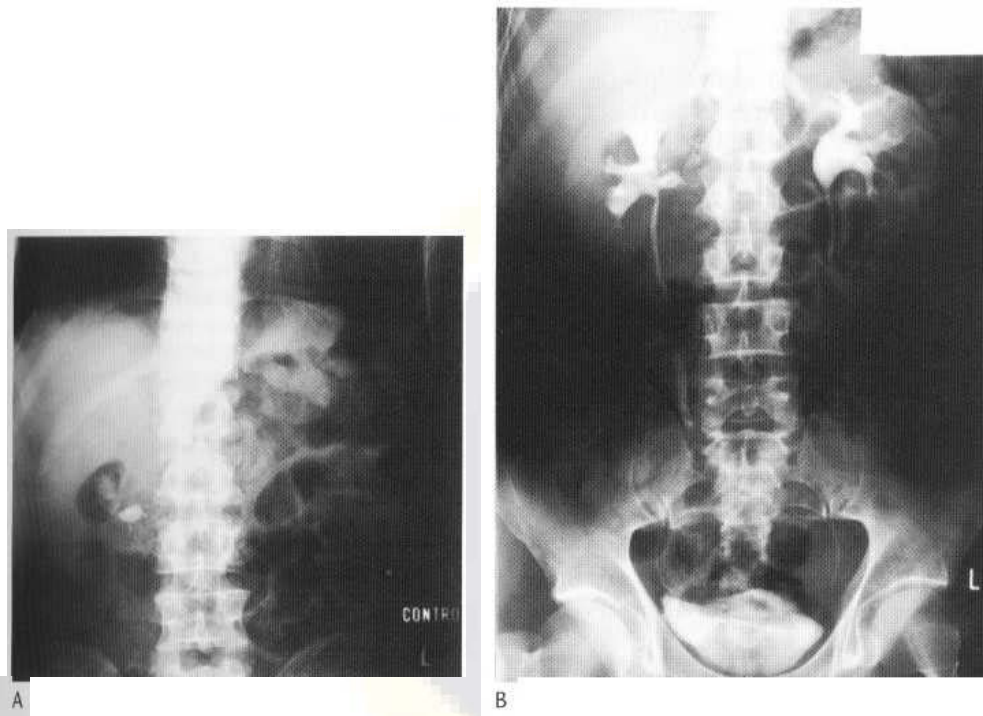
Pyeloureteritis cystica. (A) Plain films showing a renal pelvic calculus (and incidental pancreatic calcification). (B) IVU demonstrating mild hydronephrosis due to the calculus, and multiple filling defects from the pelviureteric junction downwards due to the cyst of pyeloureteritis cystica.
